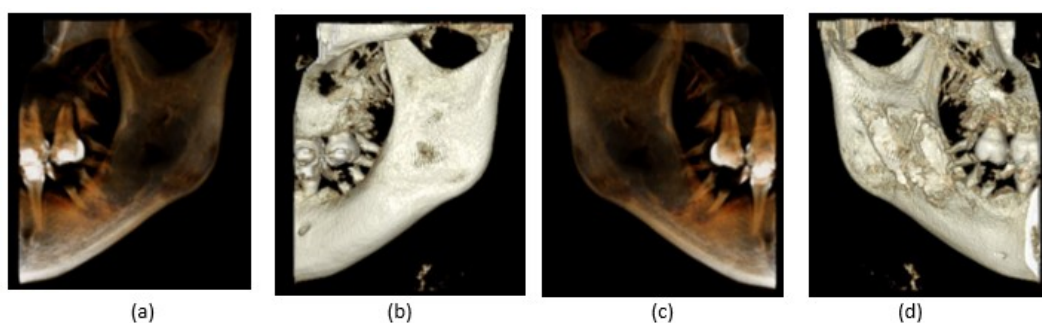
Three-dimensional (3D) reconstruction of CBCT, (a) buccal teeth view with (b) bone view, and (c) 3D lingual teeth view with (d) bone view
